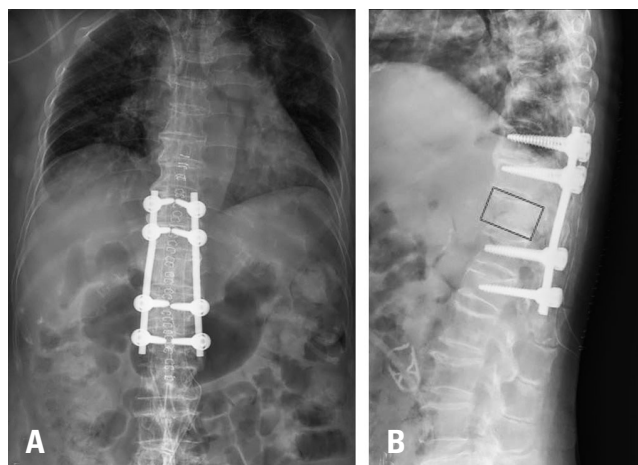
(A) Simple radiograph after posterior fusion at the T9-10-12-L1 levels. (B) Restored height of the T11 vertebral body on a lateral view (red box).
